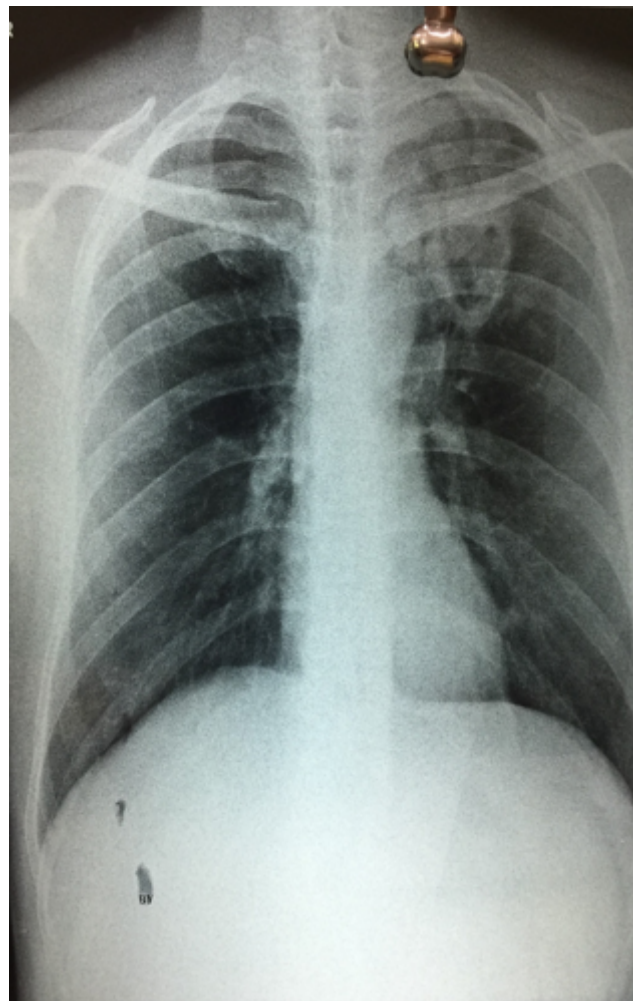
Chest radiograph showing a large oval shaped thick-walled cavity with infiltration on the left upper lung lobe
